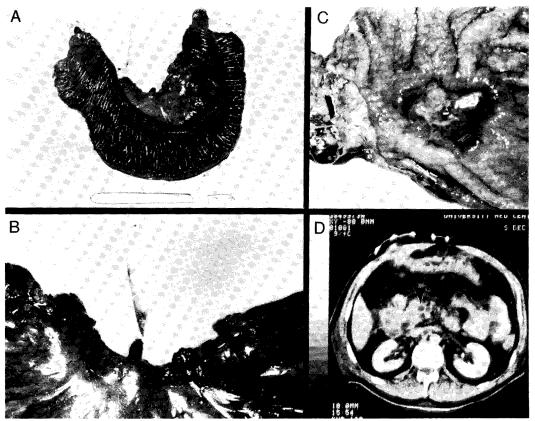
Acute pylethrombosis in a 62-year-old man with 2 weeks of abdominal pain. Despite resection of an ischemic jejunal segment (A) and distal gastric resection of an ulcerating antral carcinoma (C), progressive small intestinal infarction led to death 25 days after operation. Close-up (B) of resected jejunum shows large venous clot and abdominal computed tomography (6 days after laparotomy) shows circumferential contrast within the portal vein consistent with portal vein thrombosis (D-black arrowhead) and numerous adjacent venous collaterals (D). Acute phlebothrombosis associated with visceral carcinoma is known as Trousseau's syndrome. Reprinted with permission of the Ann. Surg. (2).
